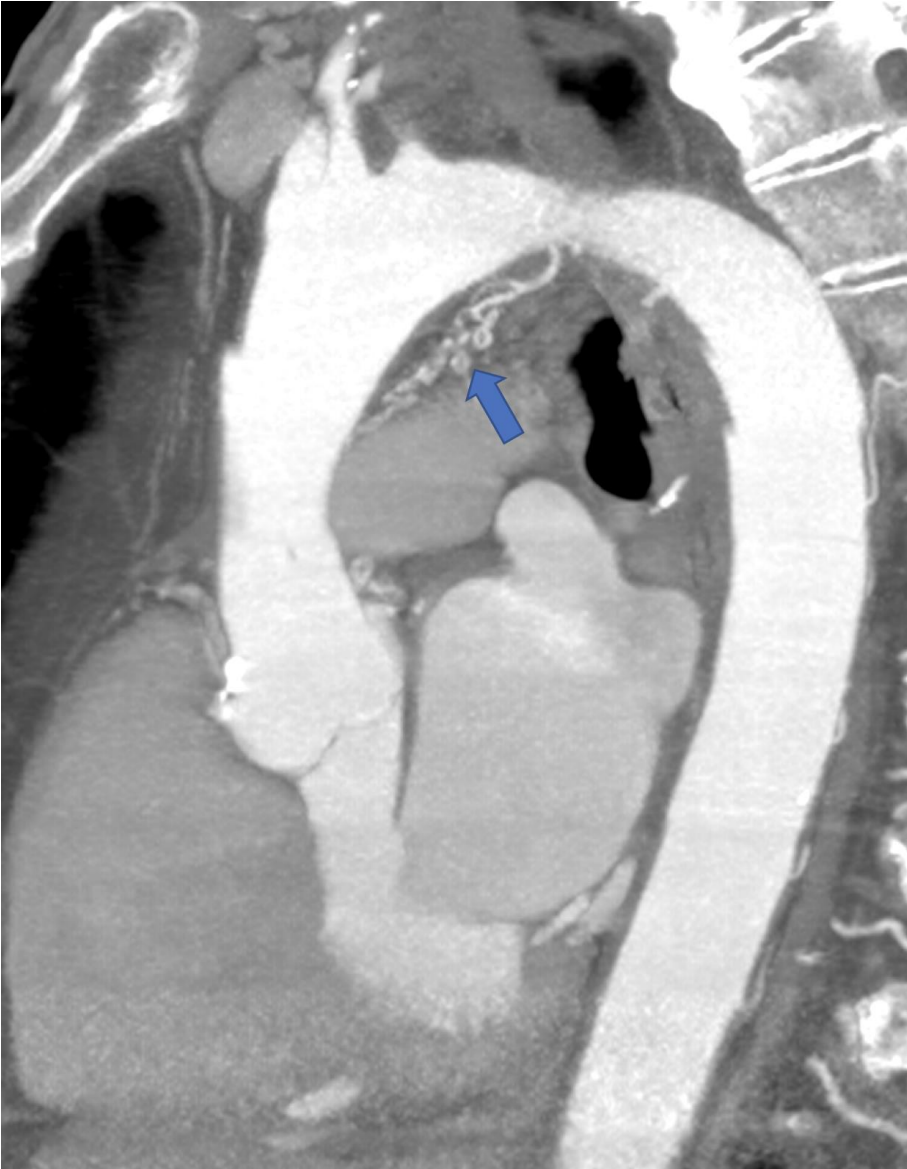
Coronary CT Scan, coronal reconstruction showing the CBF (blue arrow) originating on the lower surface of the aortic arch.
